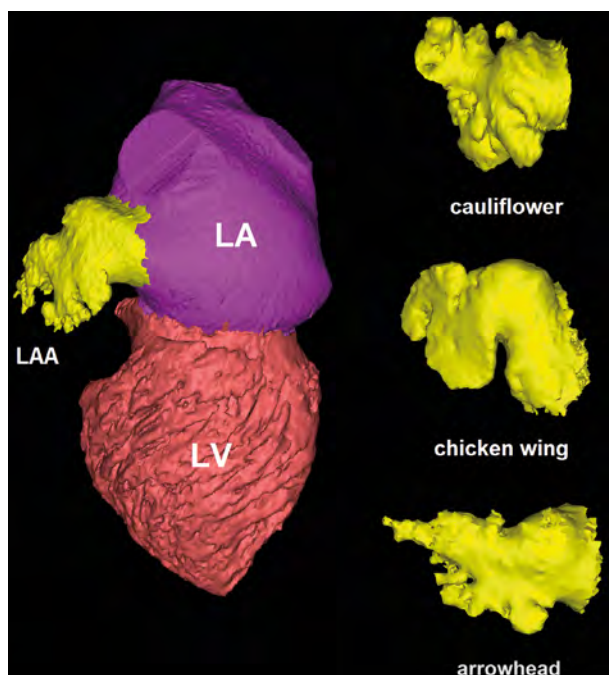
Representatives for three-dimensional reconstructions of each left atrial appendage (LAA) type (cauliflower, chicken wing, and arrowhead type), left atrium (LA) and left ventricle (LV) segmented from contrast-enhanced computed tomography of the heart (Mimics Innovation Suite 22, Materialise).
